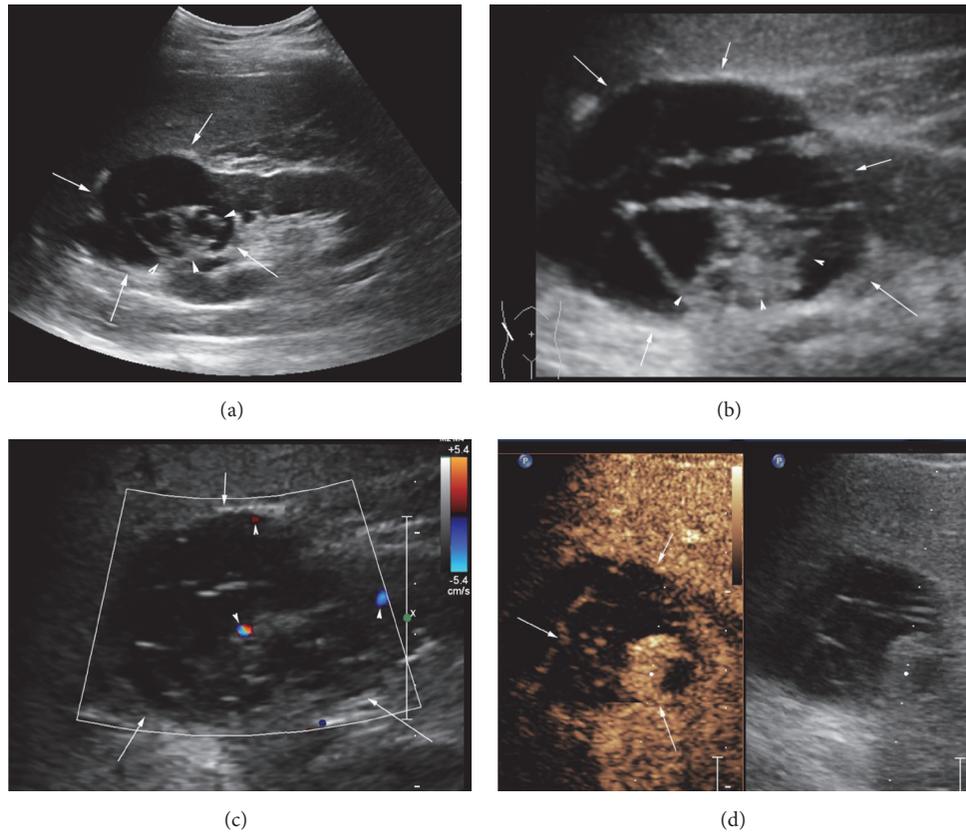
Case 2: male, 48 years old; a multilocular cystic was found in his right renal upper pole. (a) An multilocular cystic with size of $6.0 \times 5.1 \times 5.8$ cm was found (arrow) and irregular thick walls inside the tumor was displayed (arrow head). (b) By partial enlarged view, the multilocular cystic was displayed in detail (arrow) and the irregular thick wall (arrow head). (c) By color Doppler flow imaging (CDFI) mode, the cystic thick walls (arrow), the subcapsular of tumor, and the nodule inside tumor were detected by spot color Doppler signal. (d) By CEUS, the nodule inside the tumor showed hyperenhancement and the thick walls showed iso-enhancement in the early phase (arrow).
